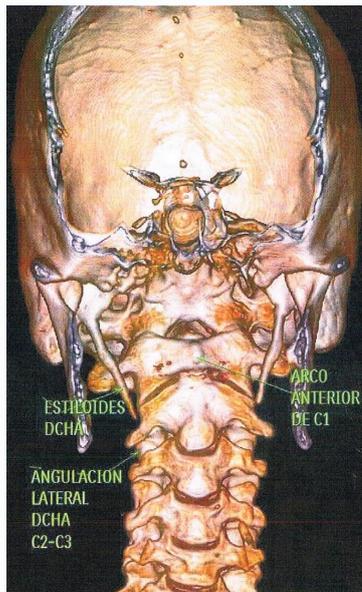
CBCT-3D. Elongated styloid process.
